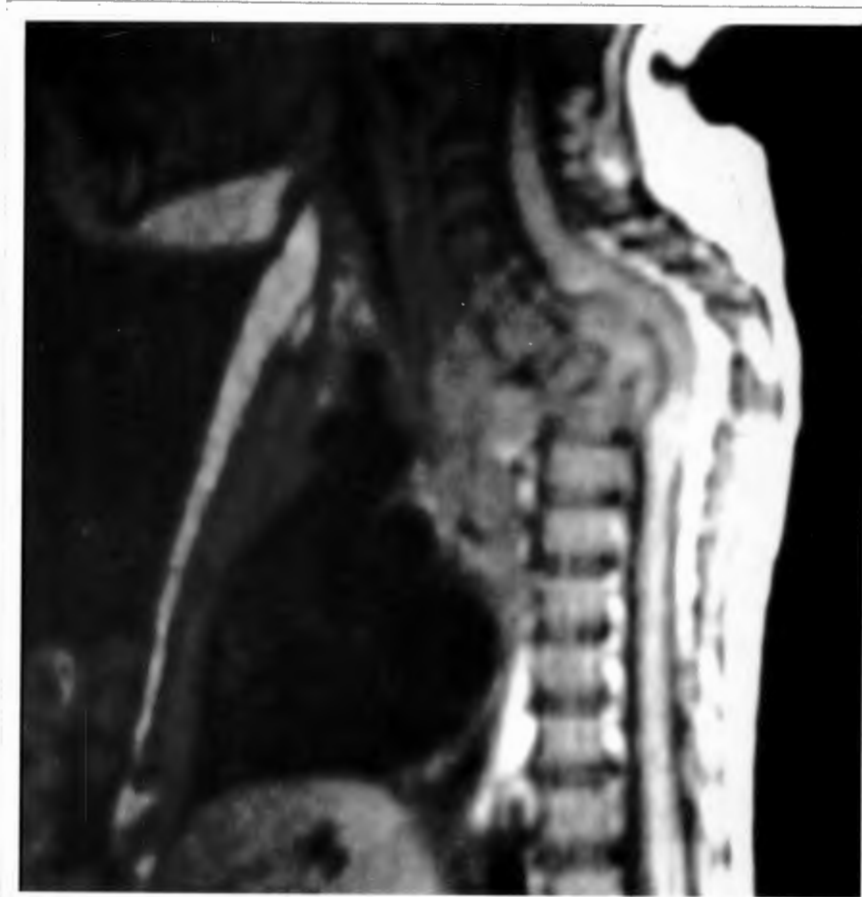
Sagittal Magnetic Resonance Imaging showing multiple vertebral body destruction in the upper thoracic region due to tuberculosis, with an extradural soft tissue collection pressing on the cord anteriorly. Note the kyphus and curvature in the cord.*
